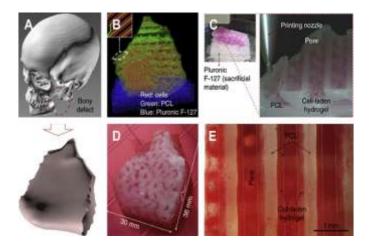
3D bioprinted human-scale mandible and calvarial bone constructs. (A) 3D computer- aided design model of mandible bony defect obtained by converting the medical computed tomography scan data
